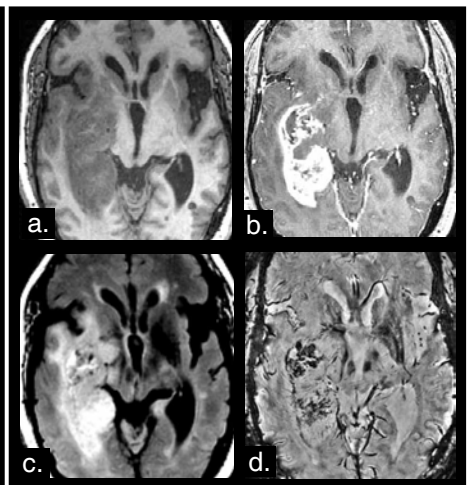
GRAPPA SWI for a glioma patient pre-therapy. In (a-c) corresponding 3T anatomical scans: (a) pre-Gd and (b) post-Gd T1 SPGR, (c) T2 FLAIR. In (d) 7T SWI.
